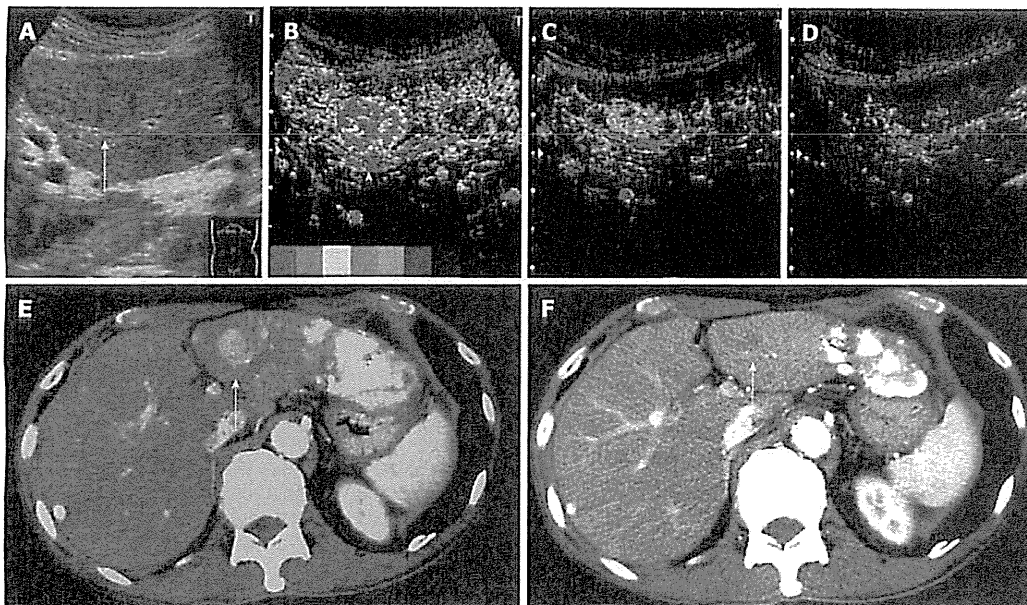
Clinical example of good responder patient. A 74-year-old man with a history of hepatitis C virus cirrhosis underwent transcatheter arterial chemoembolization (TACE) for advanced hepatocellular carcinoma three times, after which sorafenib administration (400 mg/d) was started for this patient because the tumor was TACE-refractory. A: Gray-scale ultrasonography showed a mosaic-pattern tumor sized 20 mm in diameter in S3 (arrow). This tumor was established as a target lesion; B: A large artery near this tumor was regarded as starting point (arrow head). The color mapping (CM) image before the treatment showed primarily red or orange in the tumor; C: The CM image 2 wk after the treatment showed primarily green in the tumor; D: The CM image 4 wk after the treatment showed primarily dark blue in the tumor, the same as the surrounding parenchyma; E: Dynamic computed tomography (CT) scan in arterial phase before the treatment showed a hypervascular lesion in S3 (arrow) which was the target lesion and accumulation of iodized oil in the left lobe and S7; F: Dynamic CT scan in arterial phase 4 wk after the treatment showed a hypovascular lesion in S3 (arrow) and this lesion reduced. This therapeutic response was described as a partial response.
